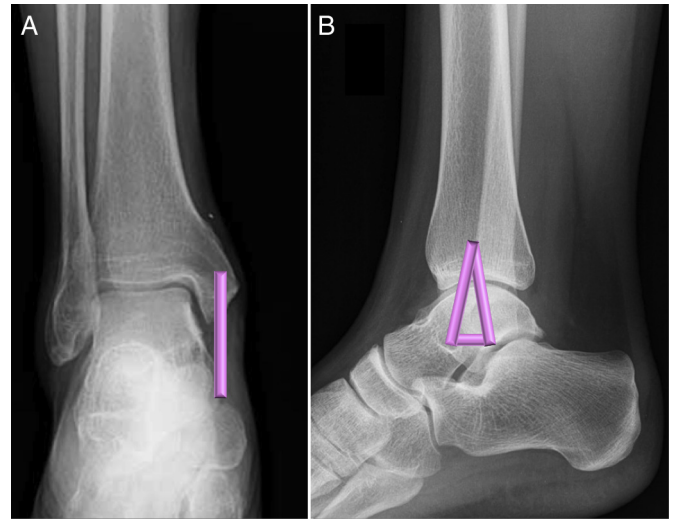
The bands or fibers of the deltoid ligament are demonstrated on (A) anteroposterior and (B) lateral radiographs. The deep deltoid ligament is orange, tibionavicular band pink, tibiocalcaneal fibers green, and posterior tibiotalar band purple.
